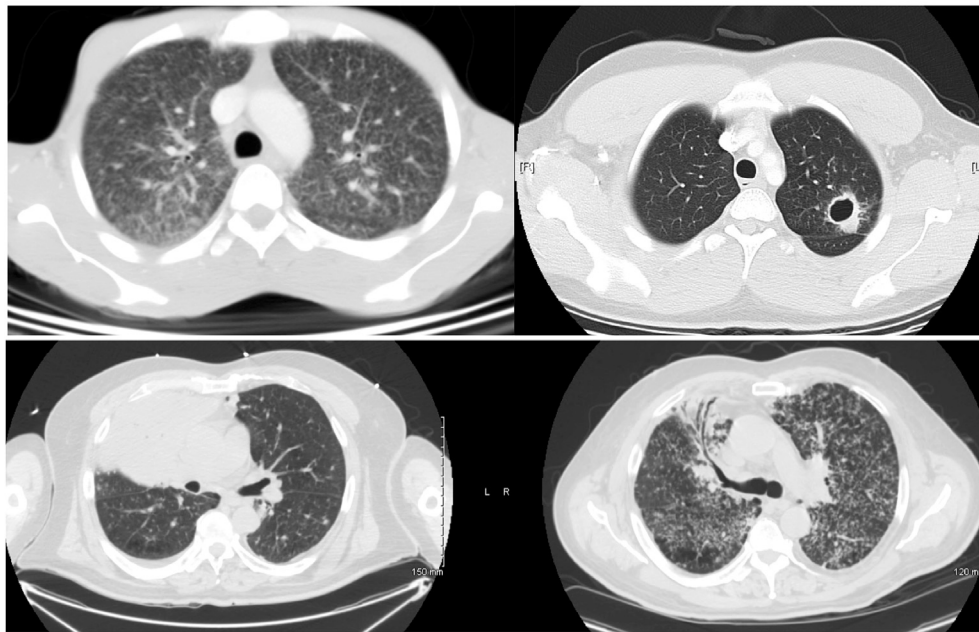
Endemic mycosis CT chest findings. Upper left: Diffuse infiltrative pattern in patient with histoplasmosis, upper right: Cavitory lesion in patient with Coccidioidomycosis. Bottom left & right: Patient with chronic pneumonia, found to have Blastomycosis. Initially mild with progression to diffuse, ground glass radiographic findings. Travelers with febrile syndrome and/or pneumonia after traveling to areas with endemic mycosis should be evaluated for fungal disease.
